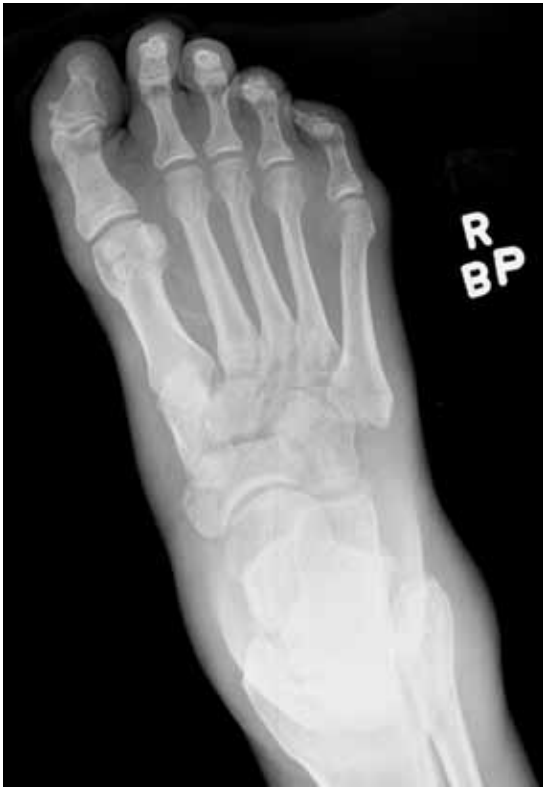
Stage 0. A plain anteroposterior radiograph taken in the emergency department shows no osseous abnormalities.
